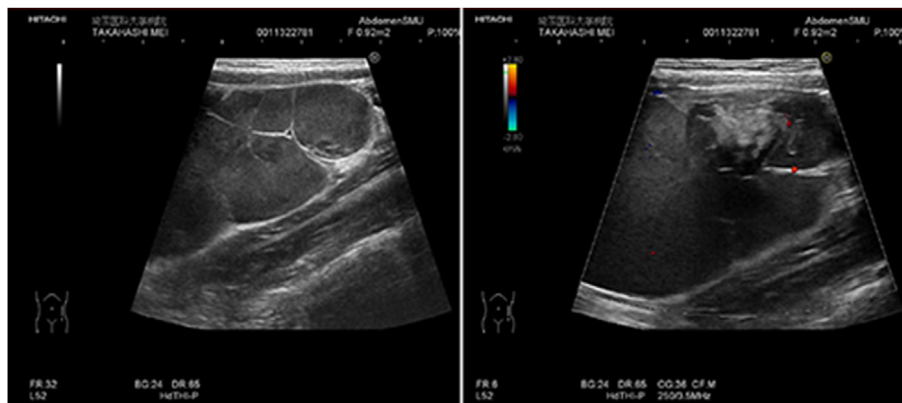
Abdominal ultrasonography. Ultrasonography revealed an echogenic tumor of 12 cm in size with a septum (Fig. 2). The tumor had multiple cysts. Color doppler ultrasonography did not detect blood flow in the tumor wall.
